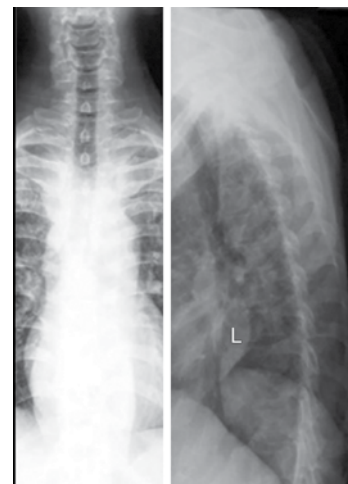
Preoperative radiographs: Anteroposterior (AP) and lateral views
